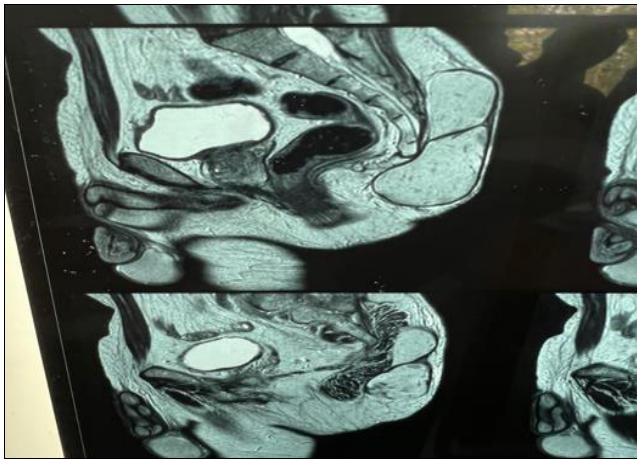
MRI picture of sacrum coccygeal region showing cystic lesion looking two lobes
